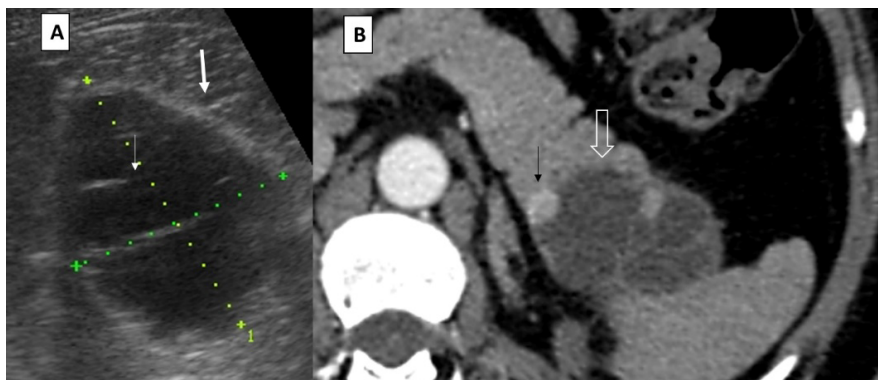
A: Abdominal ultrasound showing a predominantly anechoic cystic lesion in the tail of the pancreas, containing septations (thin arrow) and thick walls (thick arrow); B: Contrast-enhanced computed tomography showing a multisepated cystic lesion in the pancreatic tail (empty arrow), with a peripheral solid component (black arrow).
